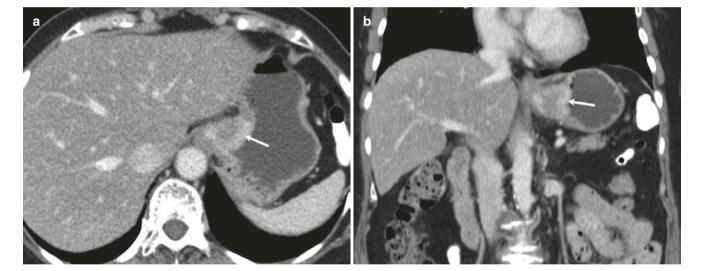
Metastasis from breast cancer. (a, b) Axial and coronal contrast-enhanced CT images show a heterogeneously enhancing ill-defined submucosal mass (arrow) in the gastroesophageal junction
